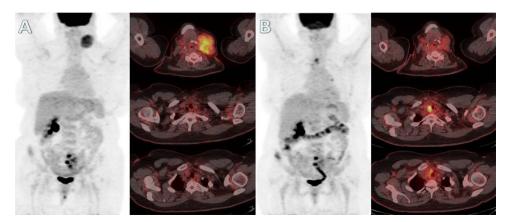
(A) Baseline FDG PET-CT. (B) FDG PET-CT done 12-weeks post dabrafenib-trametinib treatment.
